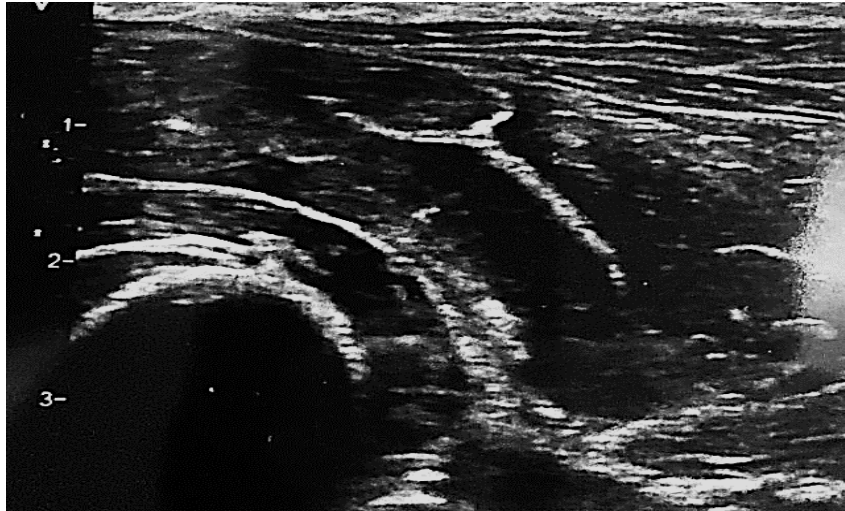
Musculoskeletal ultrasound. Edema at the insertion of the extensor muscles of the hand and fingers. (From personal archive)
